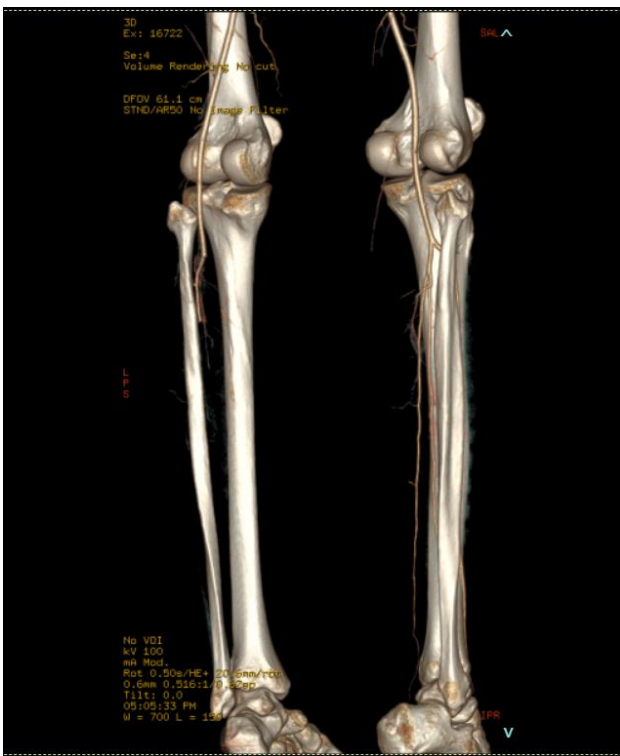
CT peripheral angiogram showing occlusion of left lower limb arteries as mentioned.
